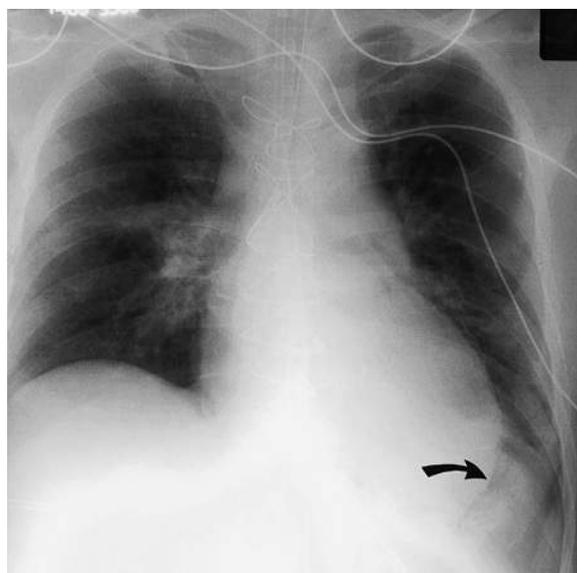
Deep sulcus sign. Portable supine radiograph in a patient status-post median sternotomy. Note the increased lucency in the left upper quadrant. The highest portion of the thorax in a supine patient is the anterior cardiophrenic sulcus; this accounts for the well-defined low cardiac border (*arrow*) and the adjacent fat pad.
